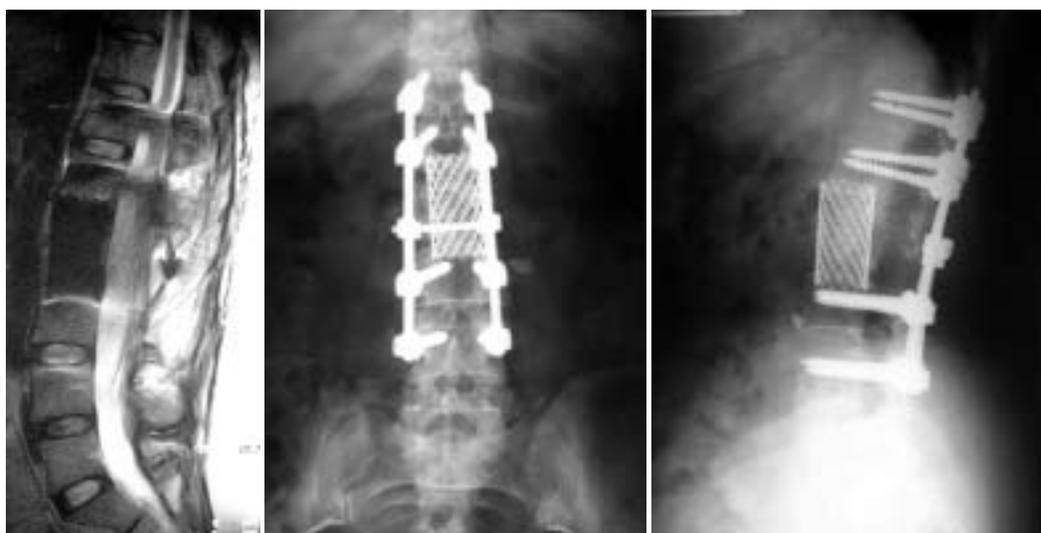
Magnetic resonance image and plain films after 5.5 years postoperatively.
